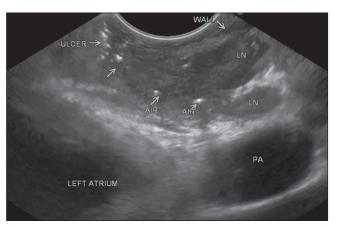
Endoscopic ultrasound guided fine-needle aspiration was done using the Pro Core (Echotip Pro Core, Cook Medical, Bloomington) 22-gauge needle using fanning technique with 10 passes. On site evaluation by pathologist revealed caseating granulomas
